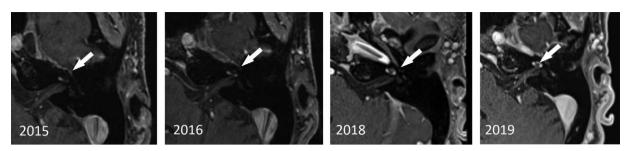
Axial-plane T1-weighted with gadolinium contrast MRI of the internal auditory canals demonstrates progressive enhancement of intracochlear schwanomma (white *arrow*), originating in the basal turn and extending to involve the middle turn. Note there is no involvement of the IAC fundus or the vestibule.
